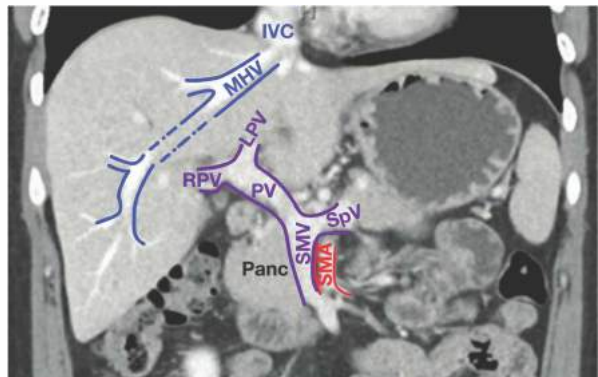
• Coronal CT demonstrating the confluence of the splenic vein (SpV) and the superior mesenteric vein (SMV) as they form the portal vein (PV). The left portal vein (LPV) makes a sharp angle from the PV, whereas the right portal vein (RPV) is more direct. Note the proximity of the SMV and the SMA to the pancreatic head. Also shown are the IVC and middle hepatic vein (MHV).
